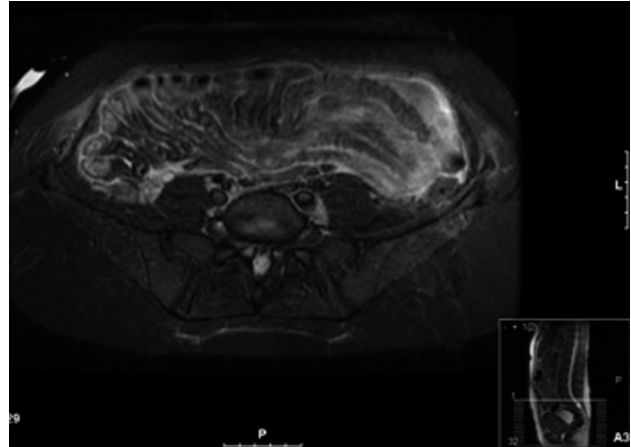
The patient's MRI image showing the extensive omental disease.
